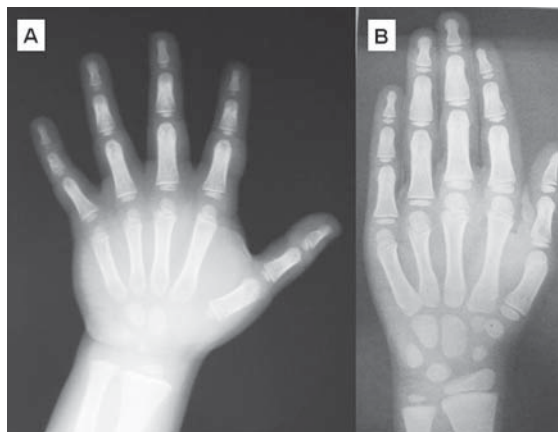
Bone age of the patient was delayed, estimated at 4 years (A). X-ray of the left wrist and hand, appropriate for patient's chronological age (B).
